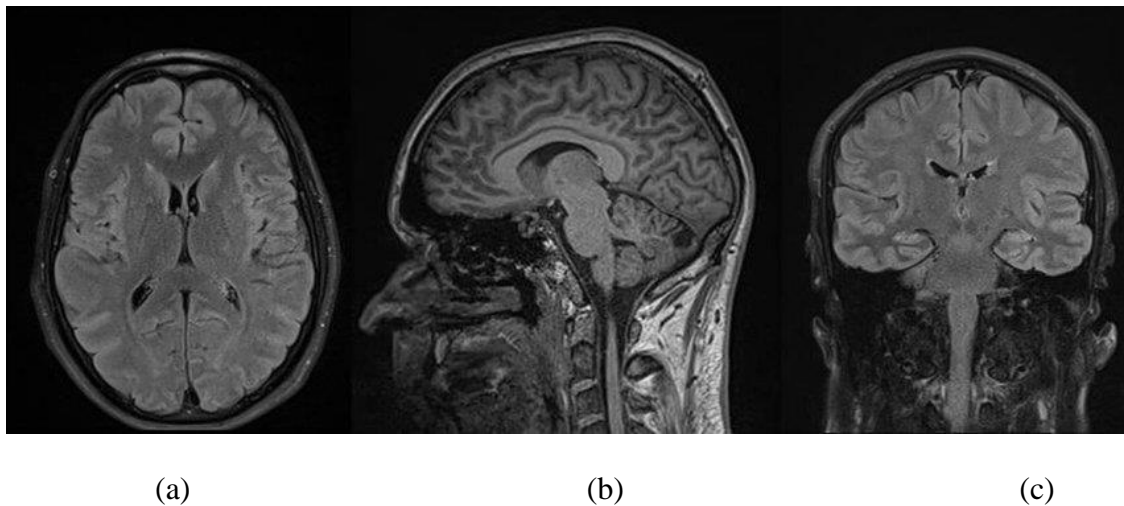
Representation of three plane views of MRI brain image:(a) Axial view, (b) Sagittal view, (c) Coronal view
